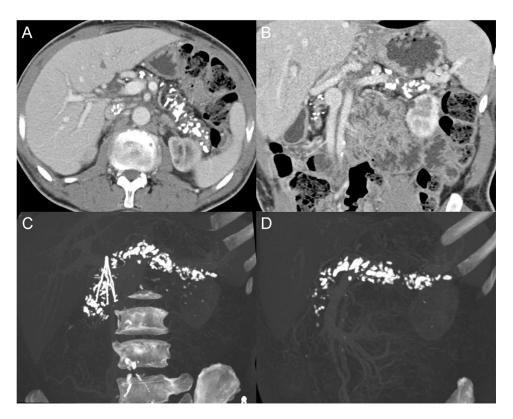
Contrast enhanced (A) axial and (B) oblique coronal reformatted CT images show severely atrophic pancreas with diffuse calcifications, compatible with chronic pancreatitis. (C) Coronal and (D) oblique coronal maximal intensity projection images show diffuse calcifications throughout the pancreas. Inferior vena cava filter overlapping the pancreatic head on (C) coronal image.
